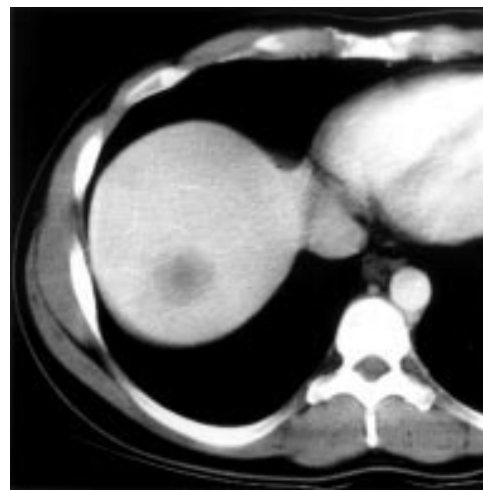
Computed tomography of the abdomen of patient 1: 4 cm hypodense lesion in the liver.
